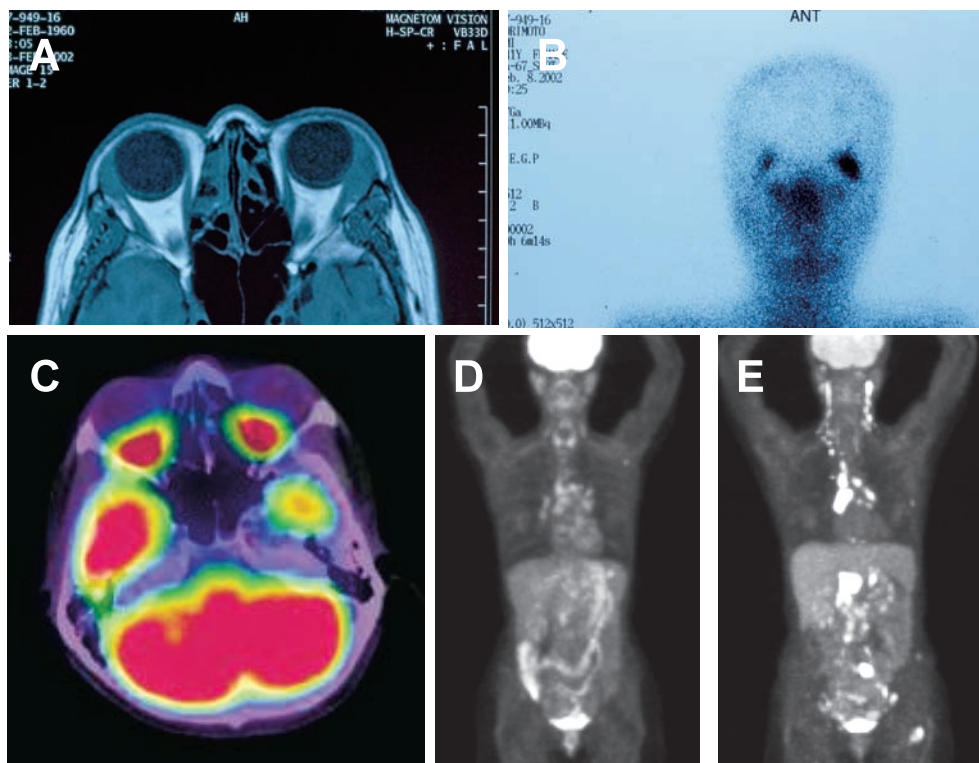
T1-weighted magnetic resonance imaging (1A), showing bilateral orbital lesions involving lacrimal glands in February 2002. Gallium scan (1B) showed abnormal uptake only in the orbit on the left side. Whole-body 2-[¹⁸F]fluoro-2-deoxy-D-glucose (FDG) positron emission tomography fused with computed tomography (PET/CT) in September 2007 showed no abnormal uptake in the bilateral orbits (1C) and systemically (1D). FDG-PET/CT in July 2010 before allogeneic hematopoietic stem cell transplantation showed numerous abnormal uptake sites in cervical, mediastinal, and abdominal lymph nodes (1E).
